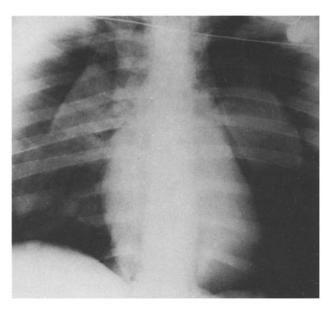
Chest X-ray demonstrates pneumothorax and pneumomediastinum. The air passage to the peritoneum is clearly shown as demarcated lines of air on both sides of the thoracic and abdominal aorta
